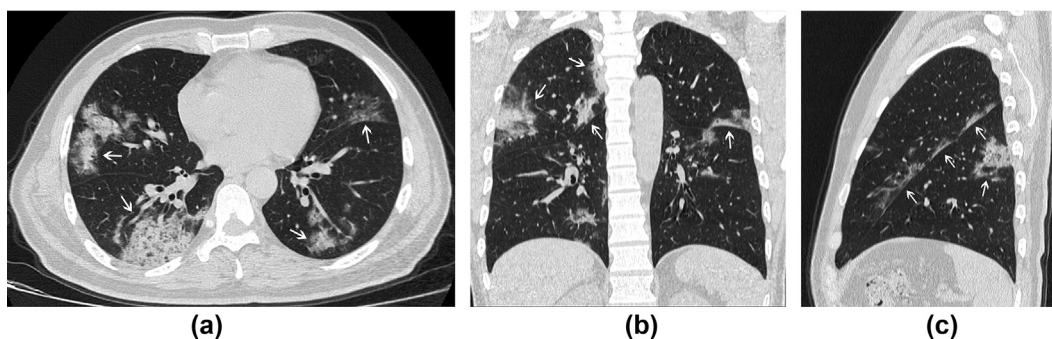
Male, 52 years old, with fever for 7 days. a), b) and c) were three-dimensional reconstructed images of chest CT examination. The lesions were mostly located in the subpleural area and stopped at the interpleural with clear margin (arrows).
